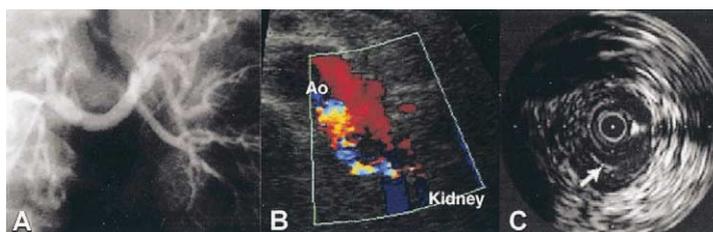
(A) Normal left renal arteriogram. (B) Transverse view at the level of the left renal artery with normal flow proximally (blue) and a narrowing and turbulent flow (spirling mosaic pattern) in the mid-portion. (C) Intravascular ultrasound demonstrating a membrane in the artery (arrow). Ao = aorta.
